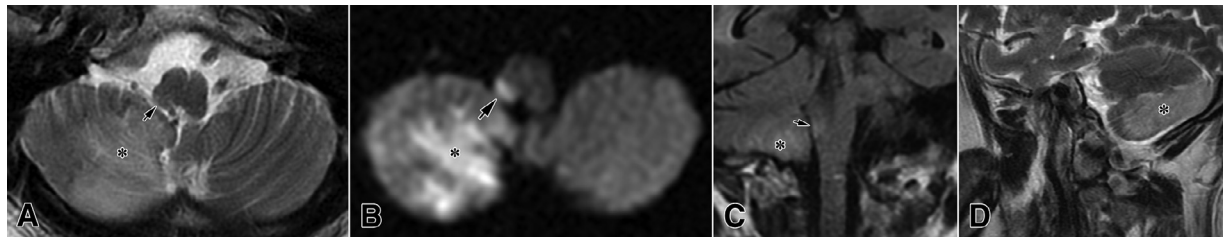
A right complete dorsal infarction (arrows) of the middle medulla in the axial T2-weighted (A) and DWI sections (B), and in coronal FLAIR (C) images. Note the ipsilateral cerebellar ischemia in all images (asterisks), including a parasagittal T2-weighted section (D).
